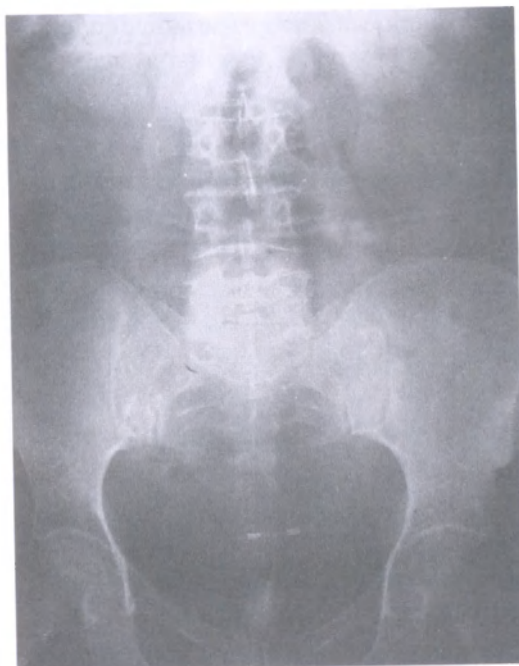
Plain radiography of abdomen
